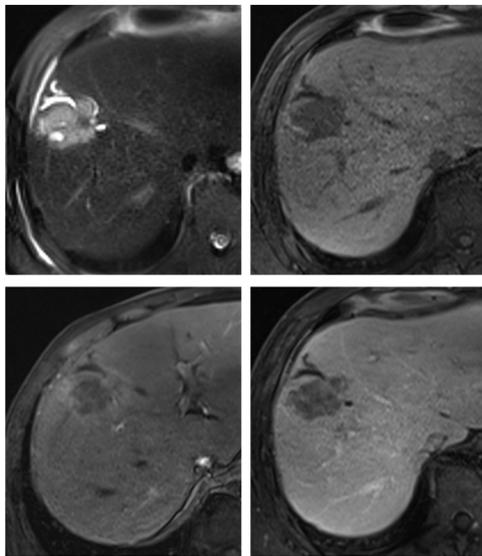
Ductal type CCA in a 67-year-old man with no known risk factors. A, B. The lobulated mass is hyperintense on the T2-weighted fast spin-echo image (A) and hypointense on the T1-weighted 3D fat-suppressed gradient-echo image (B). C, D. On the dynamic arterial (C) and venous (D) phase images, the mass shows irregular peripheral enhancement and progressive internal enhancement. Although the mass is relatively small and located periphery of the liver, the adjacent bile duct is dilated at the peritumoral area.
